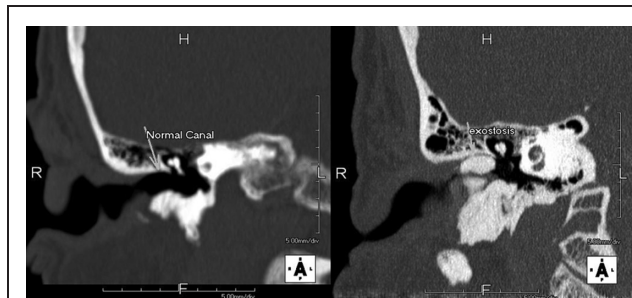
Computed tomography of temporal bones showing a normal ear canal (left) and exostoses (right)
